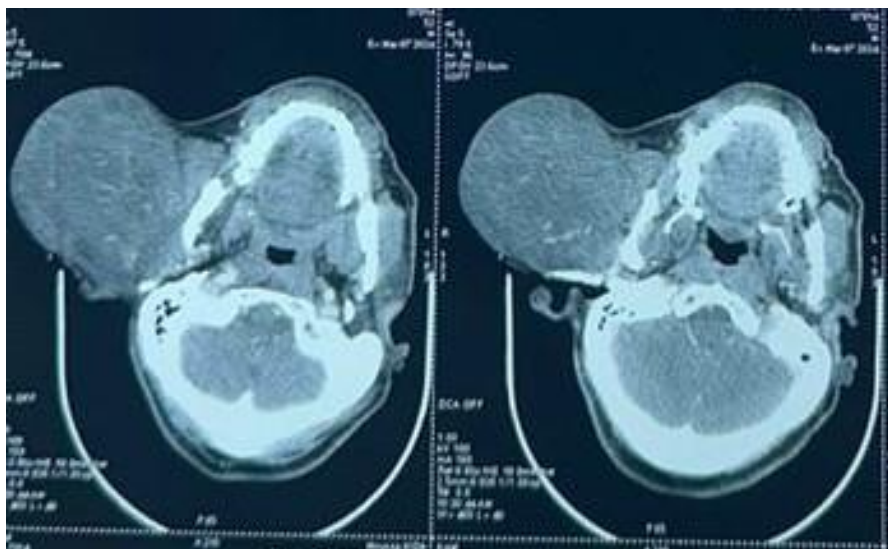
CT image showing a heterogeneous, multi-partitioned right parotid tissue mass measuring 119/104 mm, with no osteolytic lesion.
